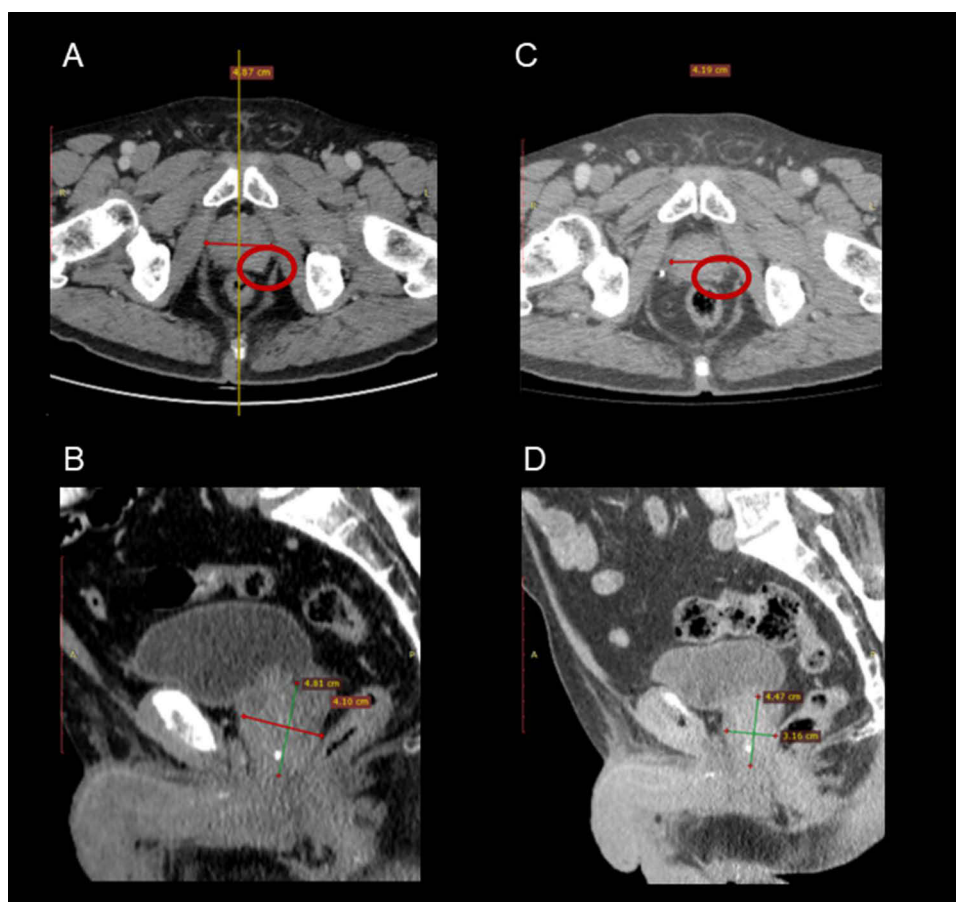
Comparison of pre- and post-therapy CT scans of the pelvis. (A and B) CT scans of the pelvis before SL-28 therapy showing the presence of clinically evident extraprostatic extension in the left lobe of the prostate. (C and D) CT scans of the pelvis after four months of SL-28 therapy showing a reduction in prostate volume, with a reduced degree of extraprostatic extension (red circle).
